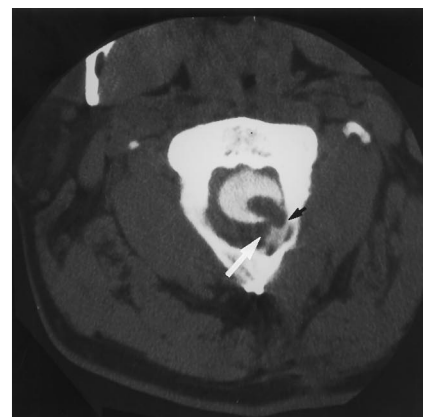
Case 5: iatrogenic spinal cord herniation after excision of a broken fixation wire without repair of the dura. Axial CT myelogram shows herniation of the cord (*small arrow*) at the C1–C2 level, dorsally to the left, with extravasation of contrast material into the dorsal epidural space (*large arrow*).
